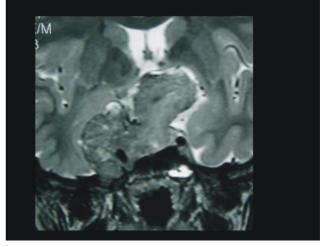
T2-weighted axial and B. coronal MR image shows a Grade III tumor. The tumor has elevated the superior wall of the cavernous sinus unilaterally.
